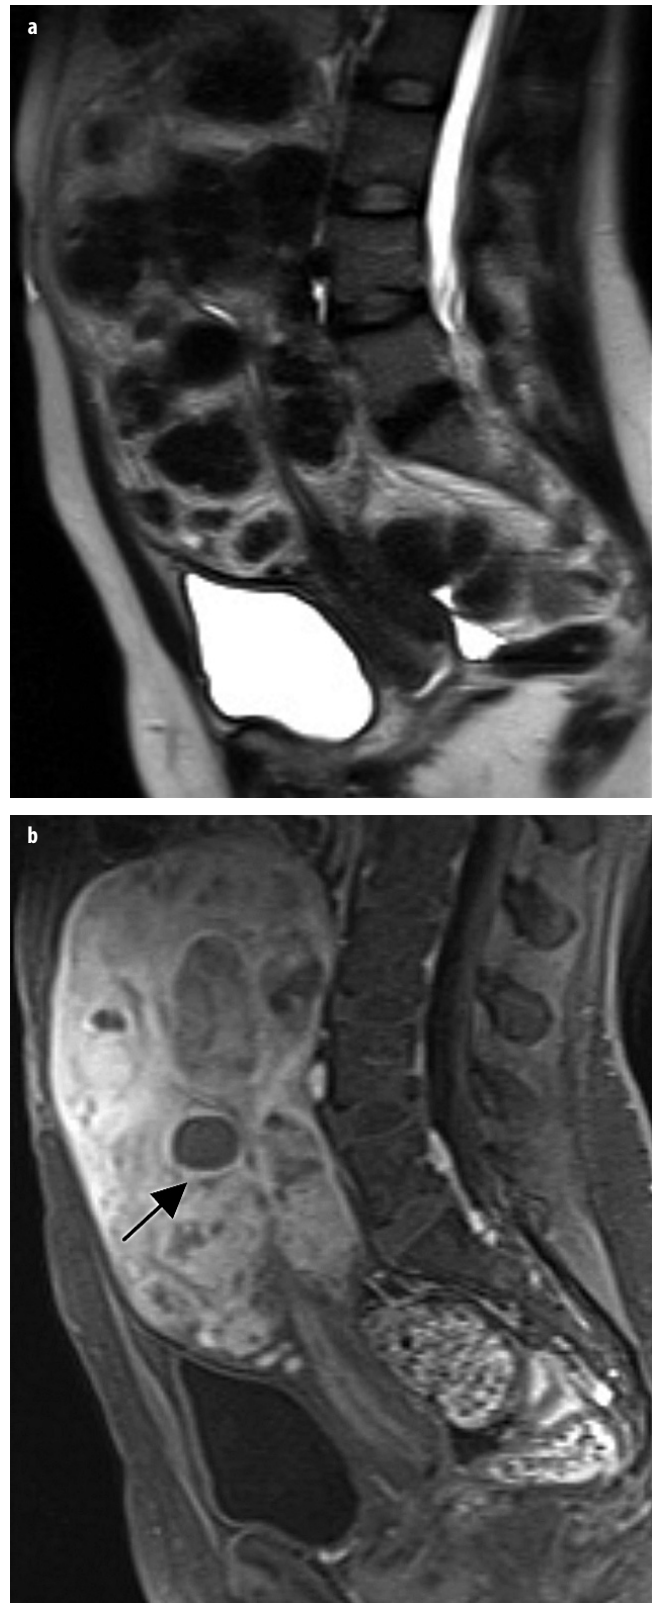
a, b. Leiomyomata. a Sagittal T2-weighted magnetic resonance image (MRI) demonstrates an enlarged uterus with multiple, well-defined low signal-intensity leiomyomas. b Contrast-enhanced sagittal fat-suppressed T1-weighted MRI shows variable enhancement of the leiomyomata. Note a degenerated avascular leiomyoma in the anterior corpus (*arrow, b*)
